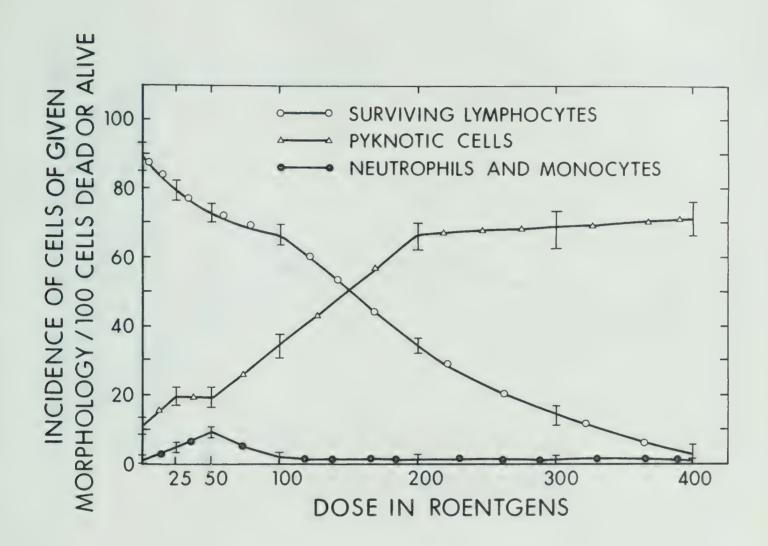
Effect of increasing single doses of X-rays, 0-400R, on incidence of surviving and pyknotic cells in culture (72 hr. post-irradiation).
